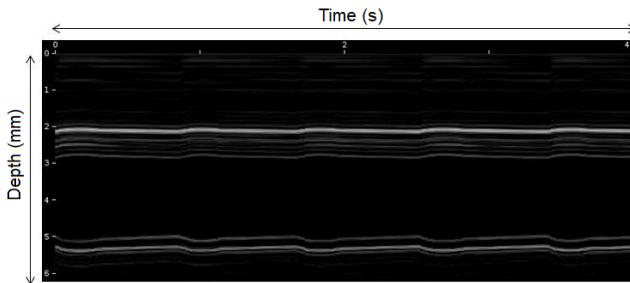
M-mode ultrasound image of radial artery.
